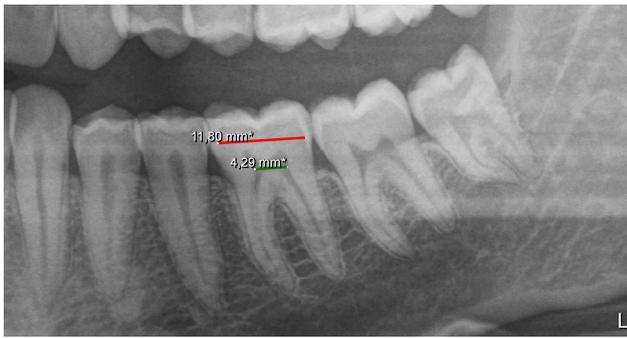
Mandibular first molar measurements on panoramic radiography. Crown width was measured from the midline of the crown without including enamel (red line). Pulp width was measured from the midline of the pulp chamber (green line).
